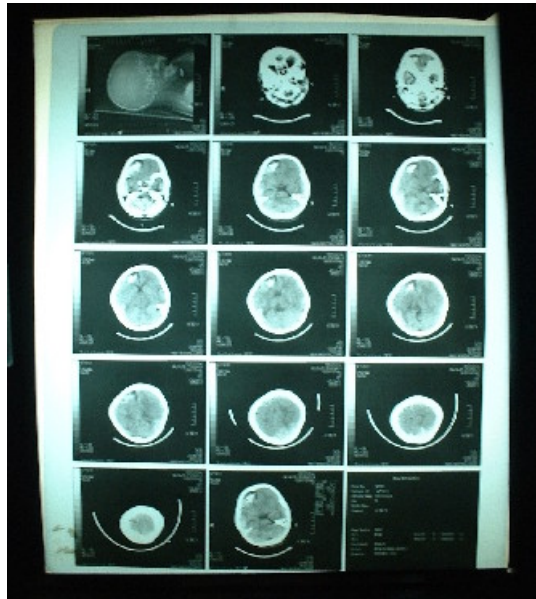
CT scan of brain showing atrophic right frontal lobe with large area of intracranial calcification in right frontal and left parietal region.
